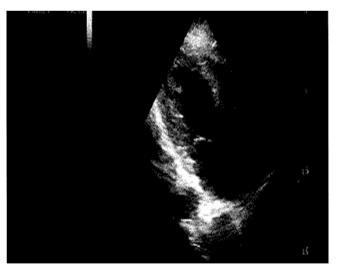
Echocardiography-Parasternal long axis view. Echocardiography showed the echogenic focus on inferior segment of myocardium.
